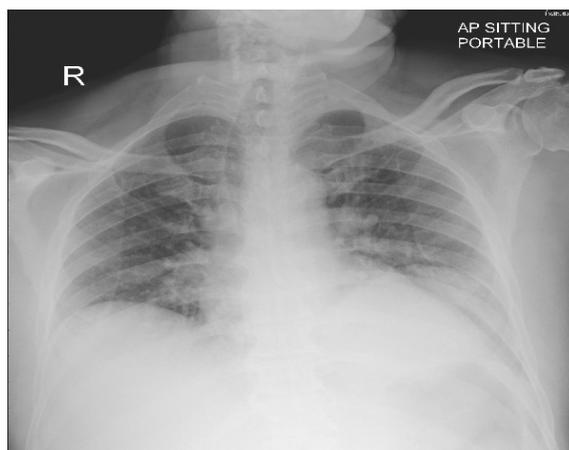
Chest X-ray with kidney shadow in left thoracic region
